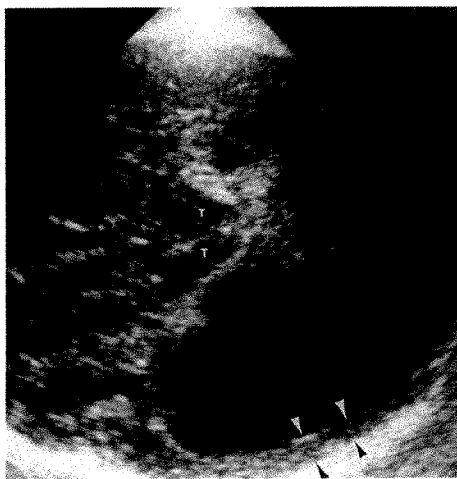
Sonogram of 34-week-old fetus shows unilateral ventricular dilatation to be greatest in occipital horn and atrium. Note thin residual cortical mantle (arrowheads). T = thalami.
